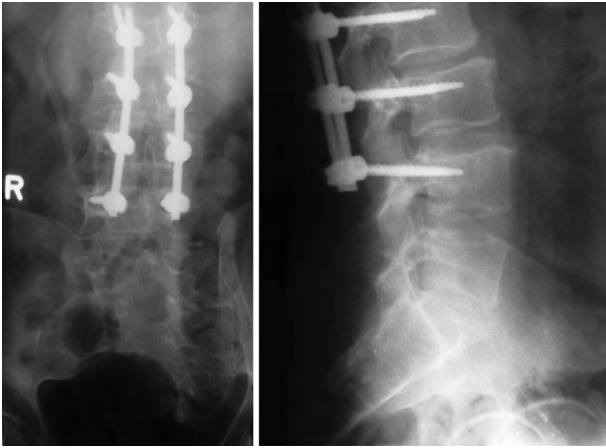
Postoperative radiographies
